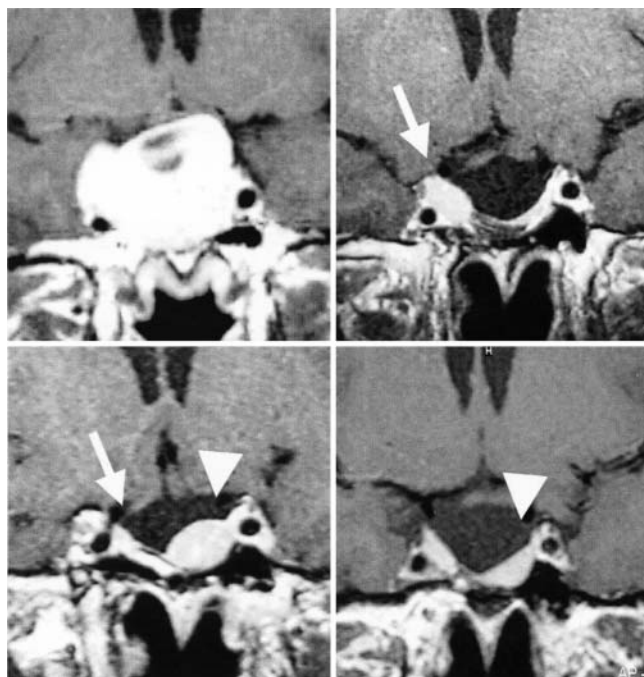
Several T₁-weighted Gd-enhanced MR images obtained in a 29-year-old man with an NPA. *Upper Left*: Tumor appearance before transsphenoidal surgery. *Upper Right*: First postoperative control image obtained 4 months after surgery. The majority of the tumor has been removed, but there is residual adenomatous tissue located in the right cavernous sinus (arrow). There is no evidence of tumor in the sella turcica or in the contralateral cavernous sinus. Gamma knife treatment was then performed, targeting the tumor in the right cavernous sinus. *Lower Left*: Follow-up image obtained 40 months after GKS. Residual tumor located in the right cavernous sinus (arrow) has markedly decreased in size, but regrowth of adenomatous tissue can be discerned in the left side of the sella turcica (arrowhead). Another GKS was performed, targeting the lesion on the left side of the sella turcica. *Lower Right*: A control MR image obtained 1 year after the second GKS. Recurrent adenomatous tissue in the left side of the sella turcica has diminished in size (arrowhead).
